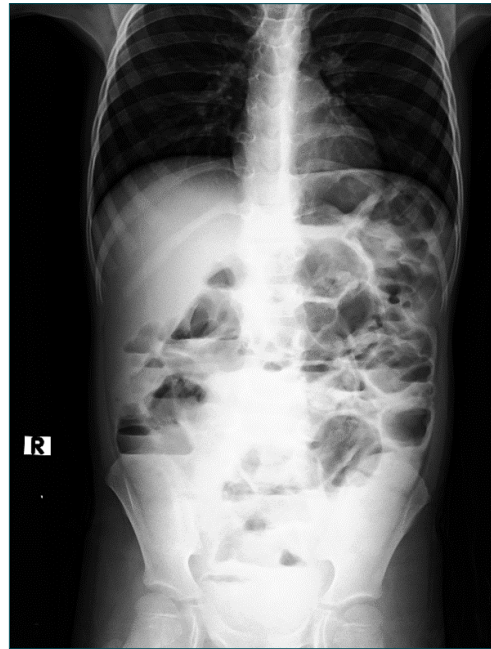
Upright abdominal X-ray showing distended jejunal and ileal loops filled with gas, and no visible foreign body present.
